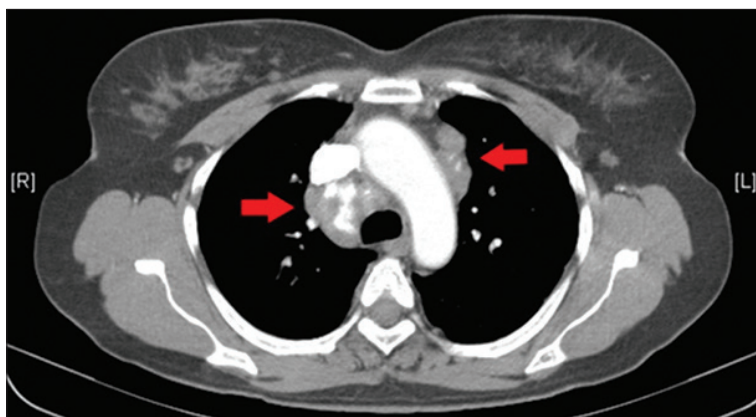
Computed tomography scan of the thorax showing bilateral mediastinal lymphadenopathy (red arrows), including calcified lymph nodes on the right.
